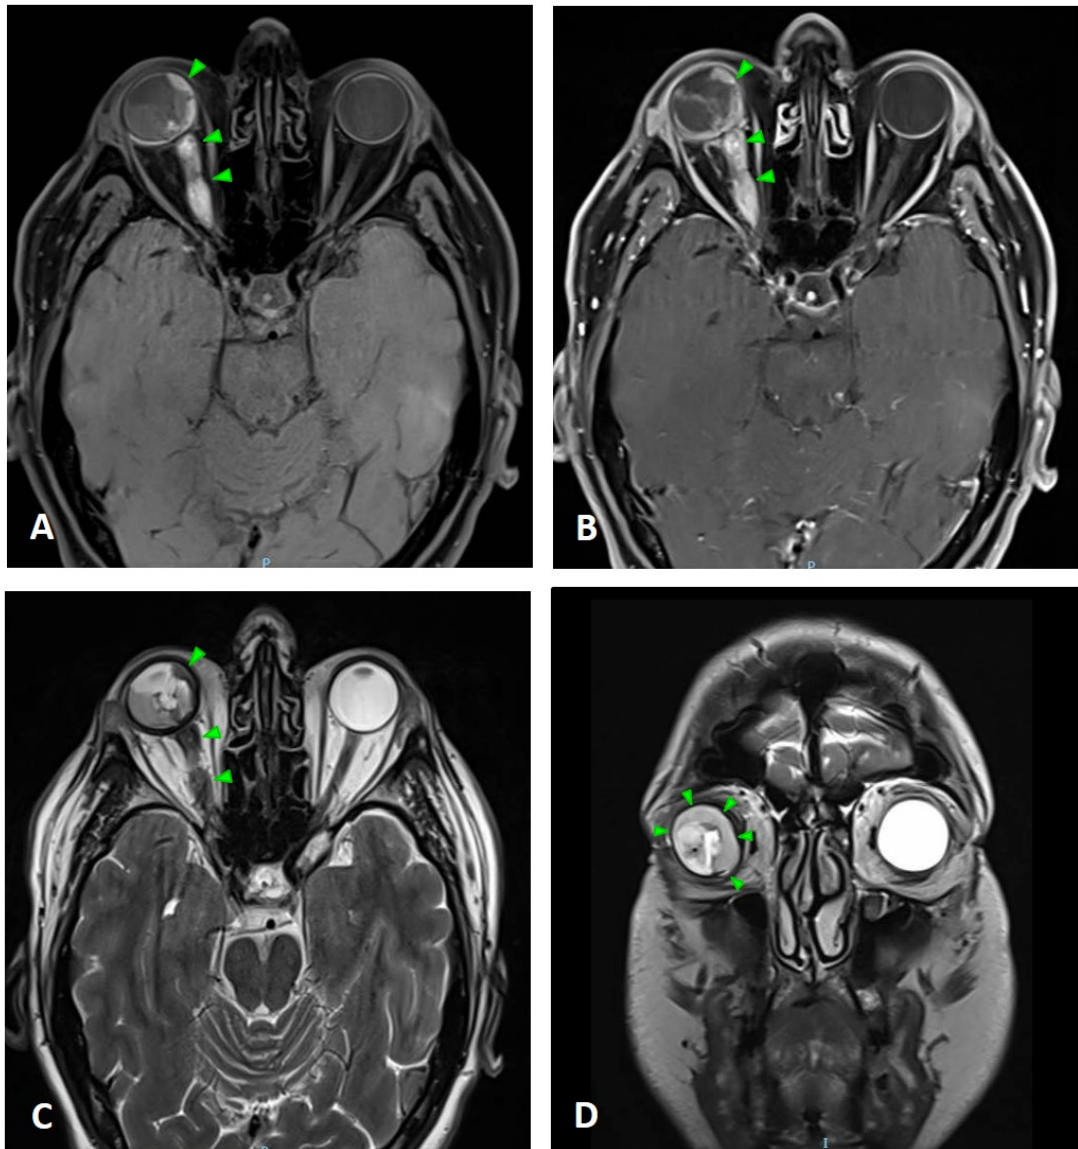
Images A, B: cranial MRI with lesion in the choroidal region of the right eyeball, hyperintense in T1 and with contrast uptake, extending to soft tissues of the orbit and ipsilateral optic nerve, suggestive of choroidal melanoma, which made ocular fundus evaluation impossible. C, D (coronal): T2 MRI.
